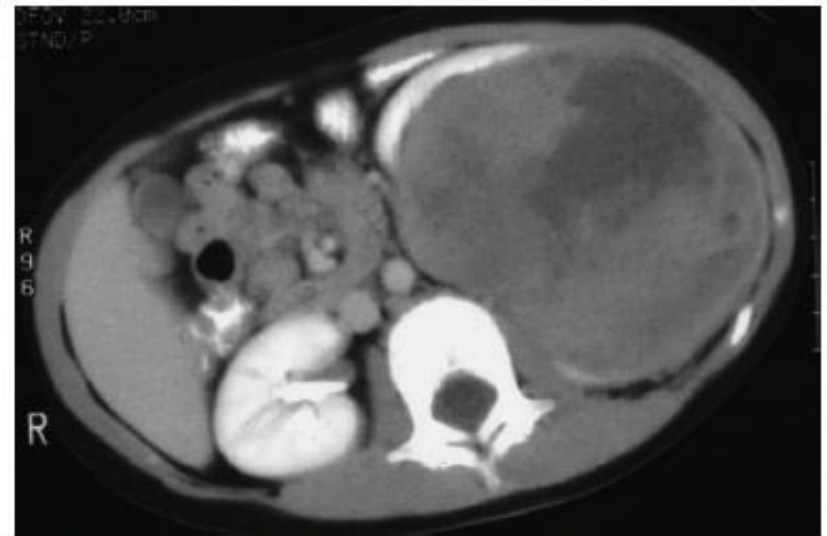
CT scan of a left Wilms tumor with a small rim of functioning renal parenchyma.
